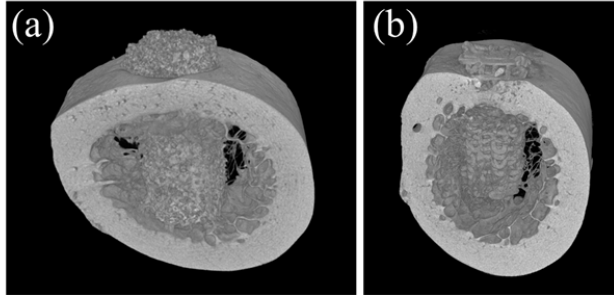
Reconstructed μ CT scans of sectioned femurs with one foamed (a) and one robocast (b) implant inside the defect, after 12 weeks in vivo.
